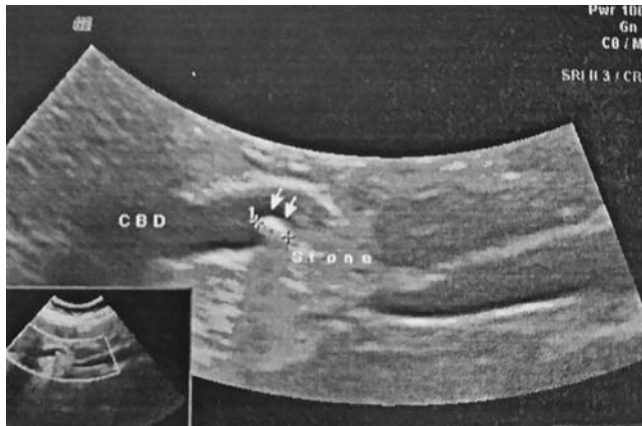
Abdominal ultrasound image in a 29-year-old woman undergoing evaluation for recurrent biliary colic shows mild dilatation of the common bile duct with a web at its distal end (arrows), misdiagnosed as a small stone. CBD, common bile duct.
